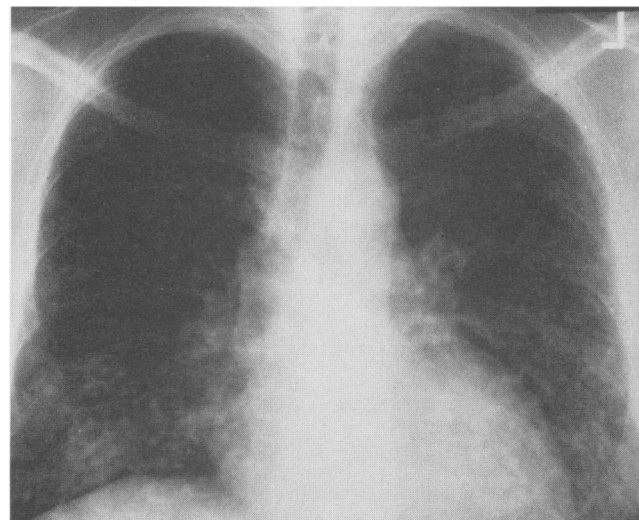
Chest radiograph of the patient in case 1 showing diffuse nodular infiltrates due to *Coccidioides immitis* infection.
